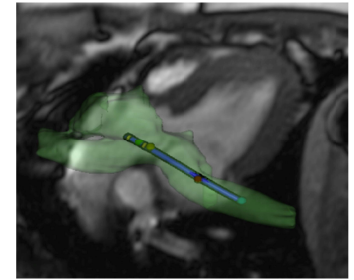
Real-time MRI display
